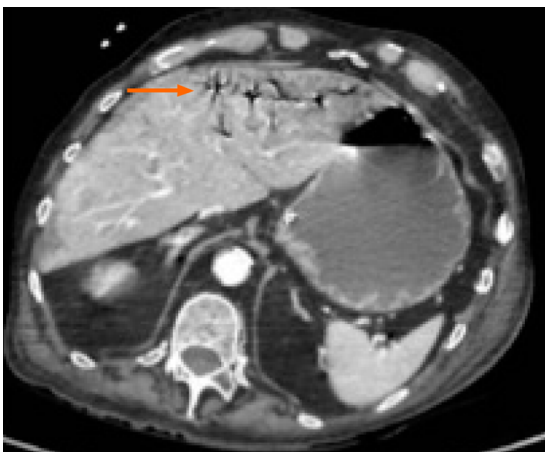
Computed tomography-scan documenting circumferential pattern pneumatosis intestinalis, identified by the orange arrow. (Personal observation).
